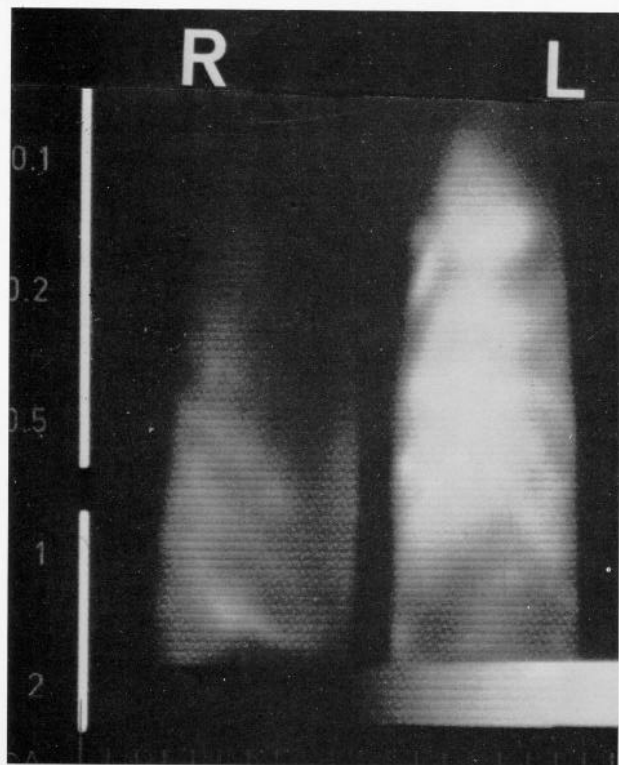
Bone tumor. An increase in calf temperature produced by bone tumor. This condition is apparent on x-ray of the bone.
